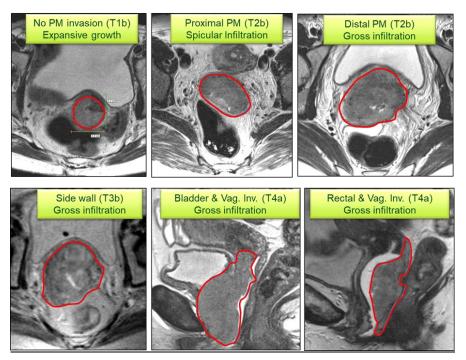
GTV T delineation on pelvic T2w FSE MRI. Representative slices in axial or sagittal plane of six different cases are shown. The cases are selected to demonstrate various patterns and extents of GTV infiltration into surrounding tissues. GTV contour encompasses the high-signal intensity lesion inside and outside the cervix, without a margin.
